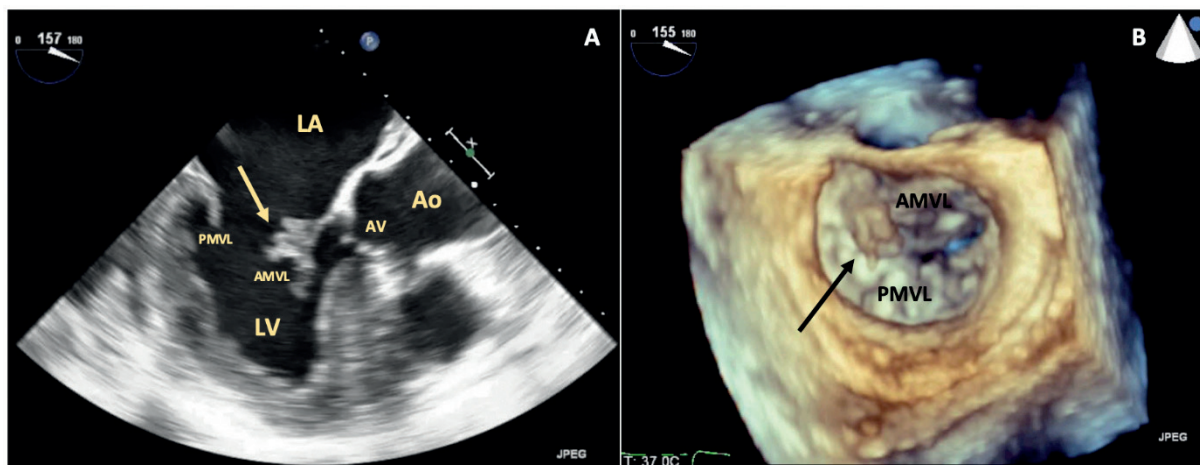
A) 2-D Transesophageal echocardiographic evaluation revealing left ventricular hypertrophy and systolic anterior motion of the mitral valve, with a polypoid mobile mass in the atrial side of the anterior valve leaflet, highly suggestive of a vegetation (→); B) 3-D Transesophageal echocardiographic evaluation, “en-face” view of the mitral valve, revealing a polypoid structure adherent to its anterior leaflet (→), corresponding to a vegetation. AMVL: anterior mitral valve leaflet; Ao: aorta; AV: aortic valve; LA: left atrium; LV: left ventricle; MV: mitral valve; PMVL: posterior mitral valve leaflet.
